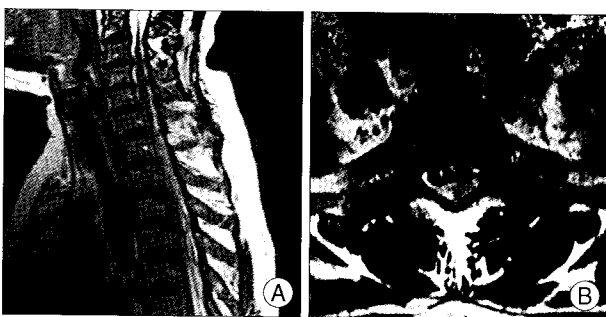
Case 2. A : Preoperative sagittal T2-weighted image shows epidural hematoma at C6-T4. B : Axial T2-weighted image shows hematoma with cord displacement.
